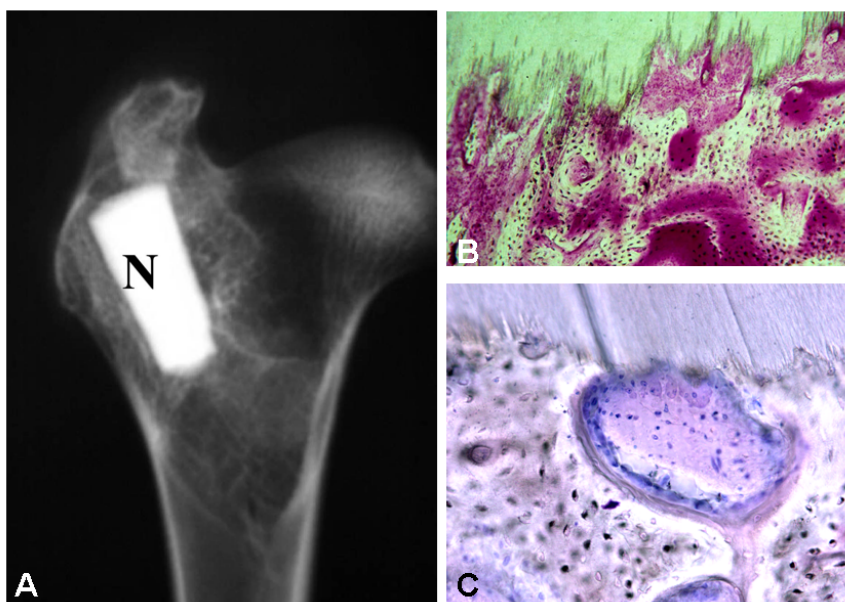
Radiographic image of the femur epiphysis harvested 10 months after implantation of a block of nacre (N) showing the preserved size and shape of the implant and the close contact between the implant and surrounding cancellous bone (A). After erosion of the implant surface nacre is in direct contact with the new formed bone (B). At the interface bone forming cells are stimulated (C) (Atlan et al, 1999).
